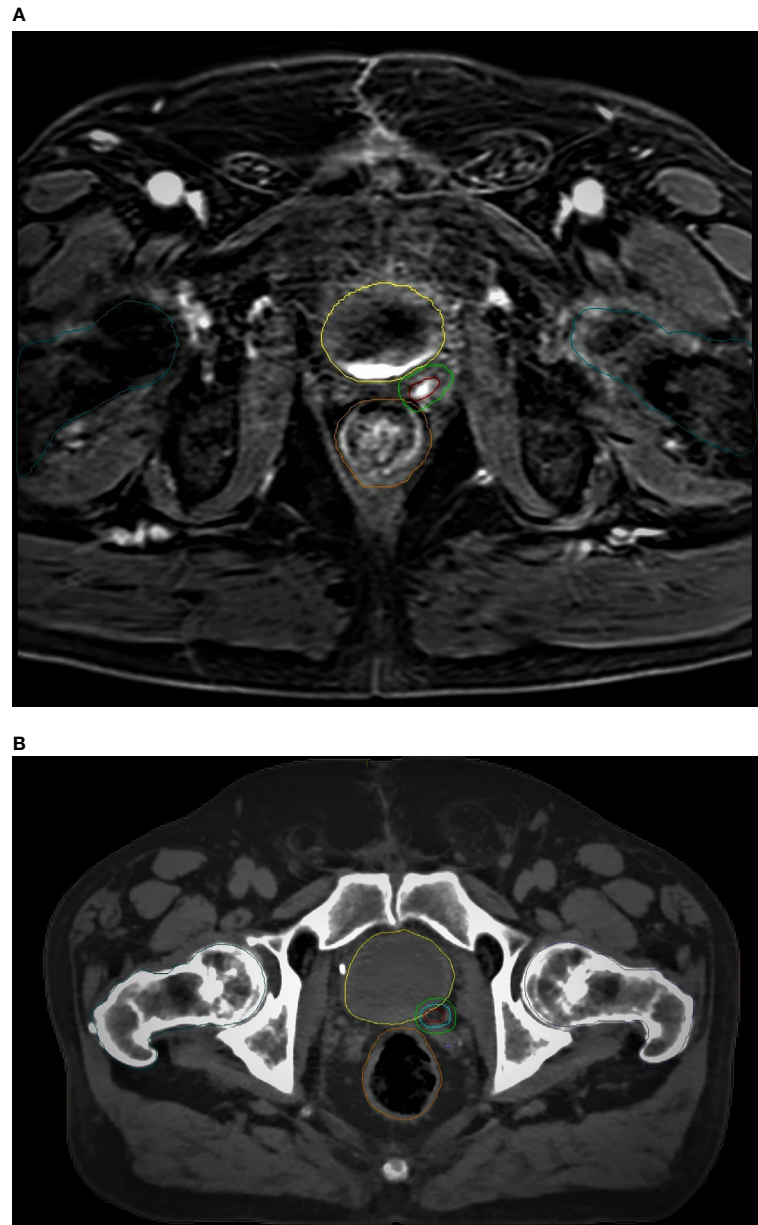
mpMRI-based (A) vs CT-based (B) GTV/PTV (boost) and OARs delineation: brown, GTV; light green, PTV (boost); yellow, bladder; orange, rectum; dark green, femoral heads.
